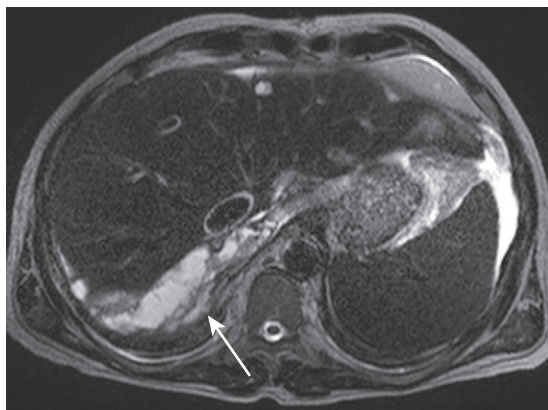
Perihepatic fluid after liver transplant. The heavily T2-weighted sequence in a patient with a recently placed orthotopic liver transplant shows a perihepatic fluid collection along the posterior margin of the liver dome (arrow).
